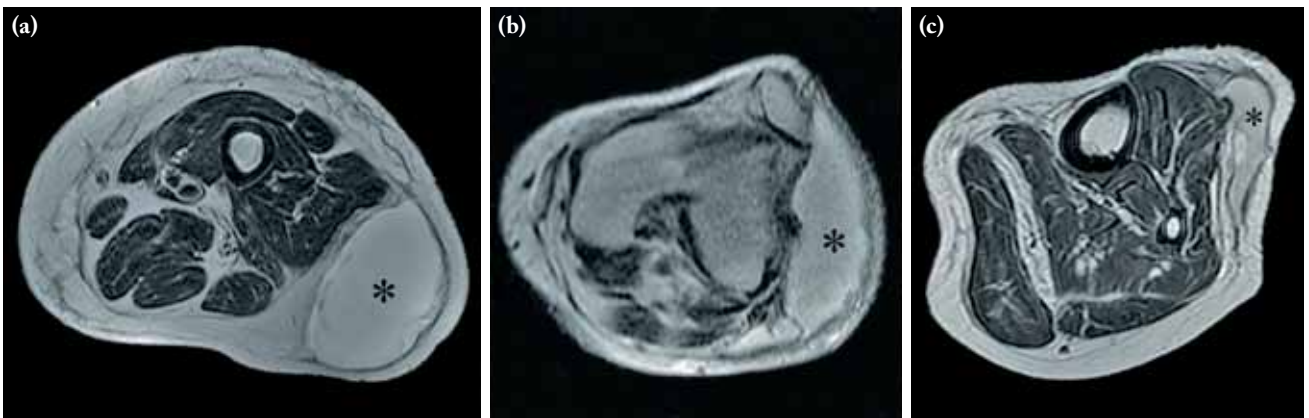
Axial T₂-weighted magnetic resonance imaging of the (a) left thigh, (b) left knee, (c) left calf. Asterisk show fluid collection.
